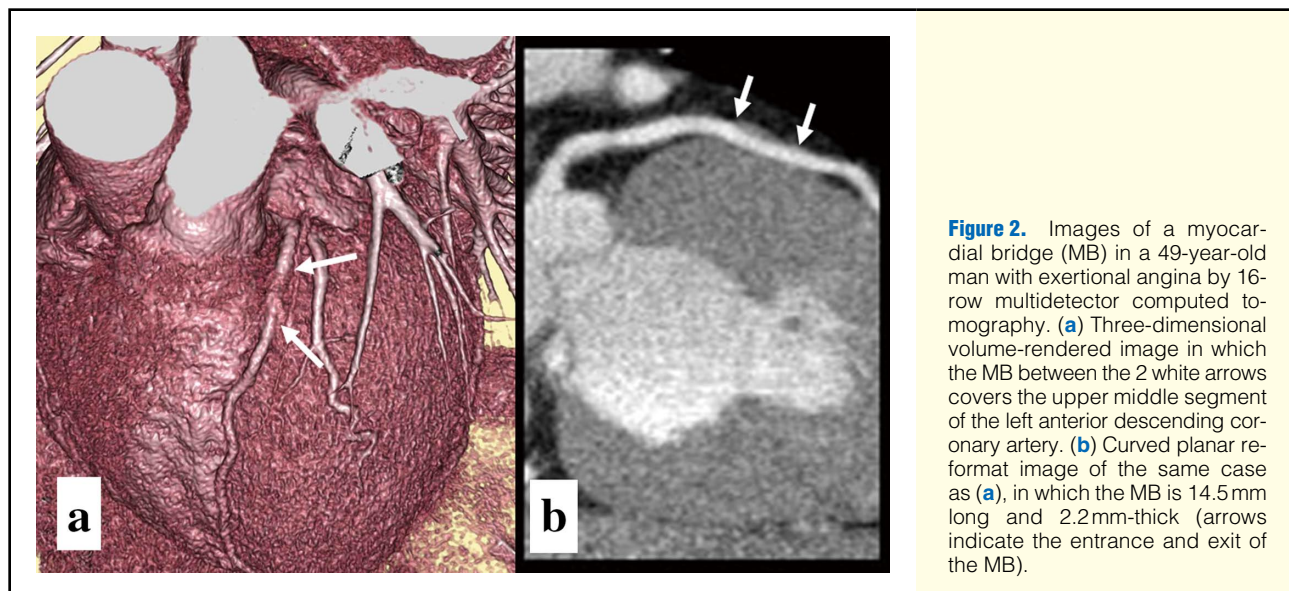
Images of a myocardial bridge (MB) in a 49-year-old man with exertional angina by 16-row multidetector computed tomography. (a) Three-dimensional volume-rendered image in which the MB between the 2 white arrows covers the upper middle segment of the left anterior descending coronary artery. (b) Curved planar reformat image of the same case as (a), in which the MB is 14.5 mm long and 2.2 mm-thick (arrows indicate the entrance and exit of the MB).
